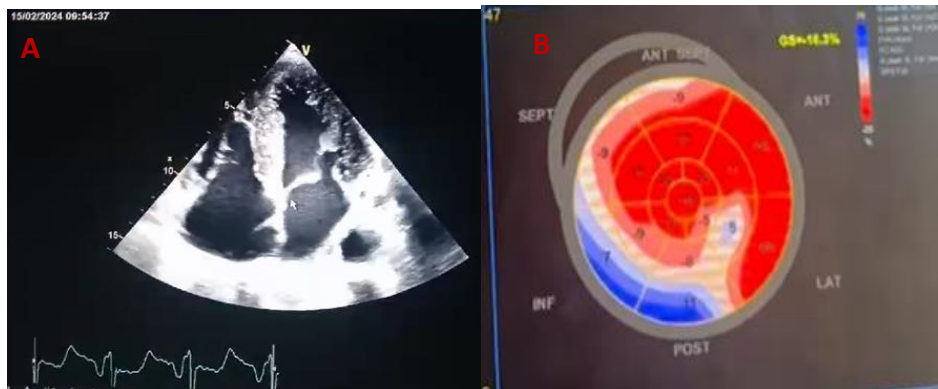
A and B. Transthoracic echocardiography (TTE) showing a hyperkinetic left ventricle with a left ventricular ejection(LVEF) fraction of 64%,Global longitudinal strain of -16.3%, concentric left ventricle hypertrophy with a brilliant appearance of the interventricular septum
